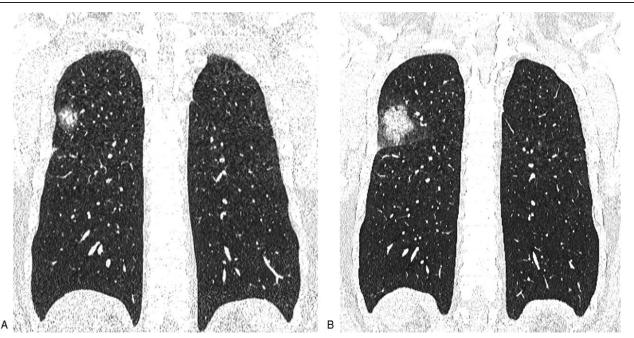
A 26-year-old male patient. A, The first computed tomography (CT) scanning showed a single ground glass opacity (GGO) in subpleural of right inferior lobe, with higher-density nodule shadow in uneven density. B, The second CT scanning showed the lesion area increased from smaller to larger, which indicated progress of disease.
